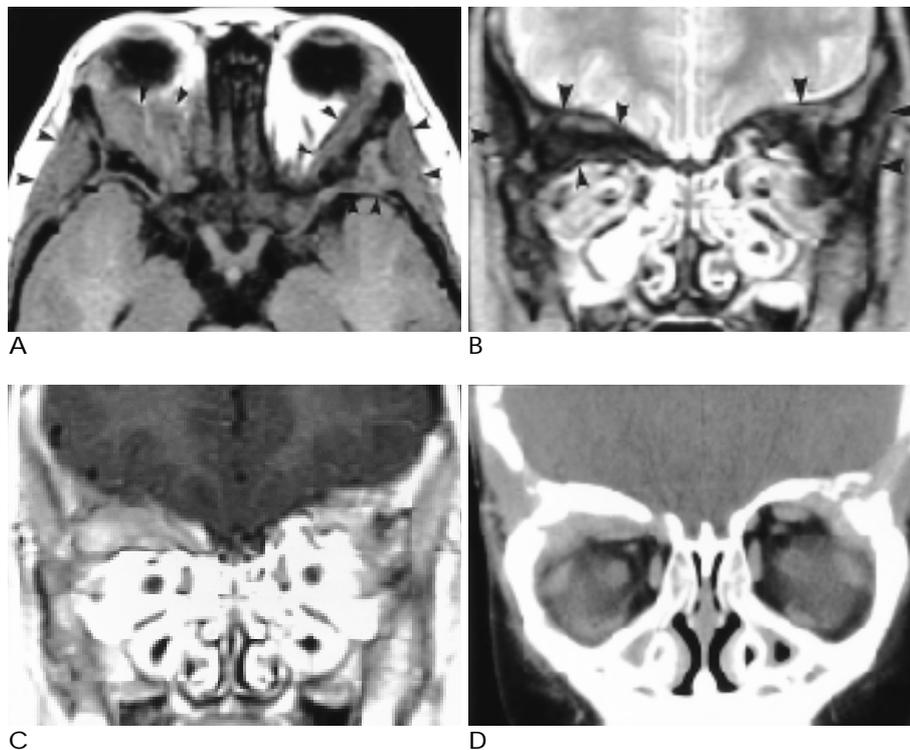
Case 4. Three-year-old girl presented with poor oral intake. MR T1-weighted image (A) and T2-weighted image (B) show iso-signal intensity masses with bone destruction (arrowheads) involving superolateral wall of both orbits. Postcontrast T1-weighted coronal MR image (C) shows marked enhancement of soft tissue mass. Enhanced coronal CT (D) shows irregular bone destruction with soft tissue masses involving superolateral orbital wall bilaterally.
